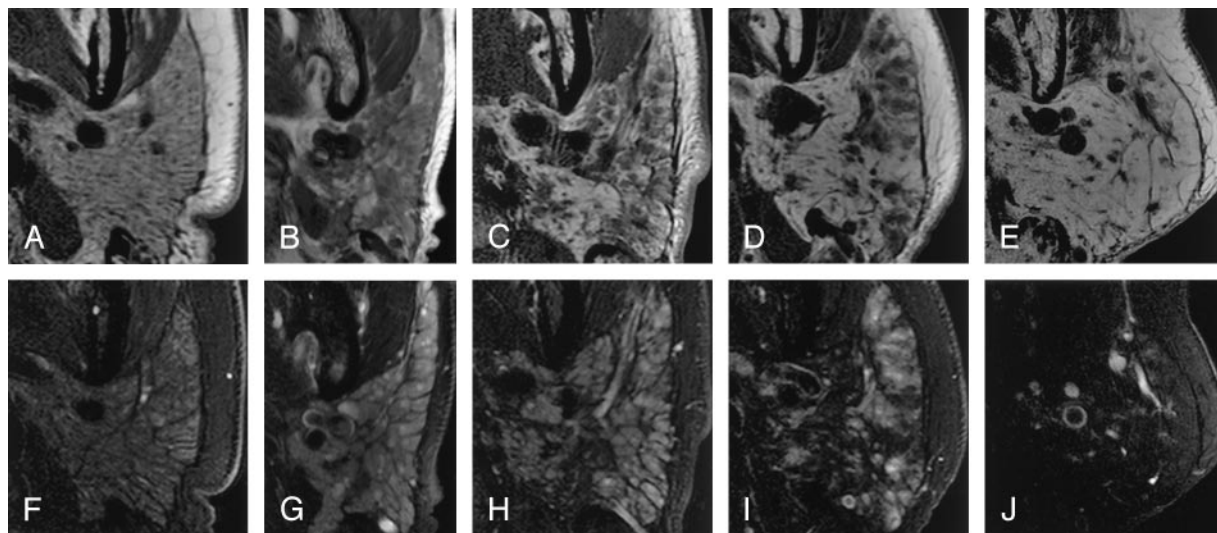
MR imaging features of the parotid glands relative to conventional sialographic grades in xerostomia patients with or without Sjögren's syndrome.
